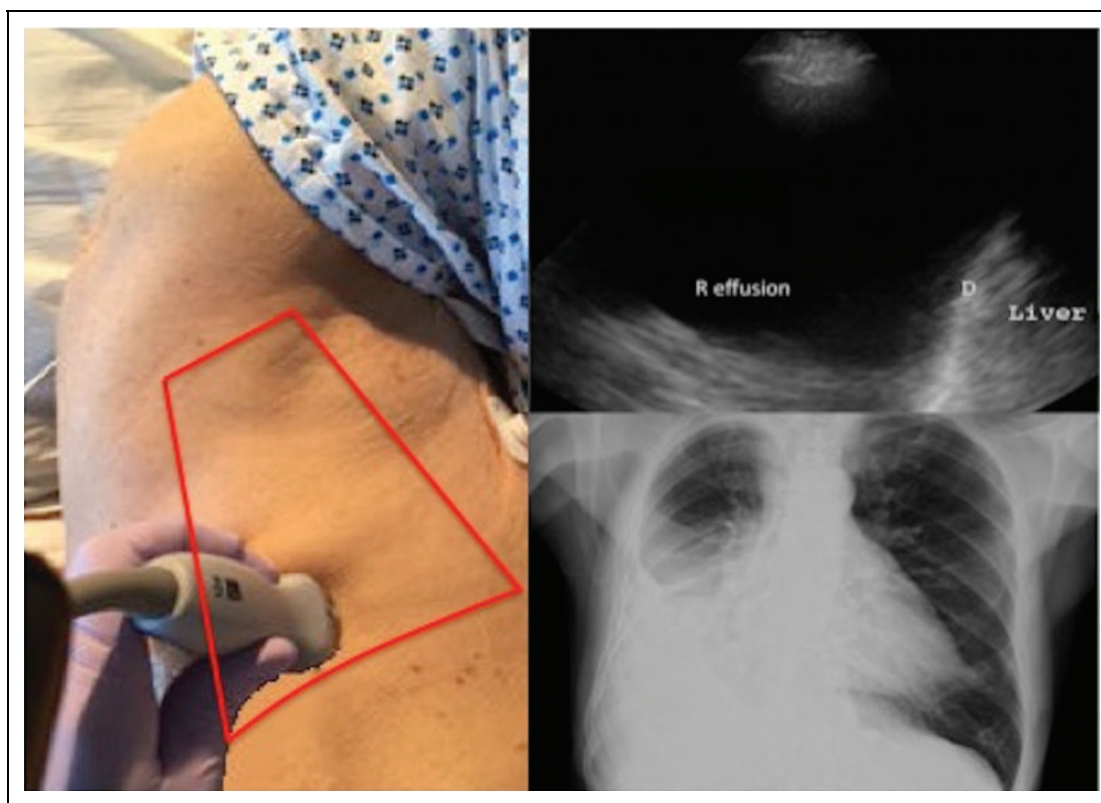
Correct ultrasound position for thoracentesis in the triangle of safety (left); ultrasound image identifying landmarks including the right pleural effusion (R effusion), diaphragm (D), and liver (right upper); chest X-ray demonstrating large right pleural effusion (right lower).
